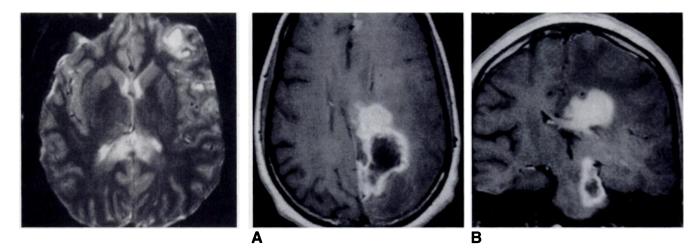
Traumatic shear injury of the corpus callosum in a 17-year-old boy. Axial T2-weighted (3000/80) MR image shows diffuse axonal injury involving the splenium of the corpus callosum. It was hyperintense on T1-weighted images, indicating a hemorrhagic shear injury. Another contusion is present in left frontal pole.
